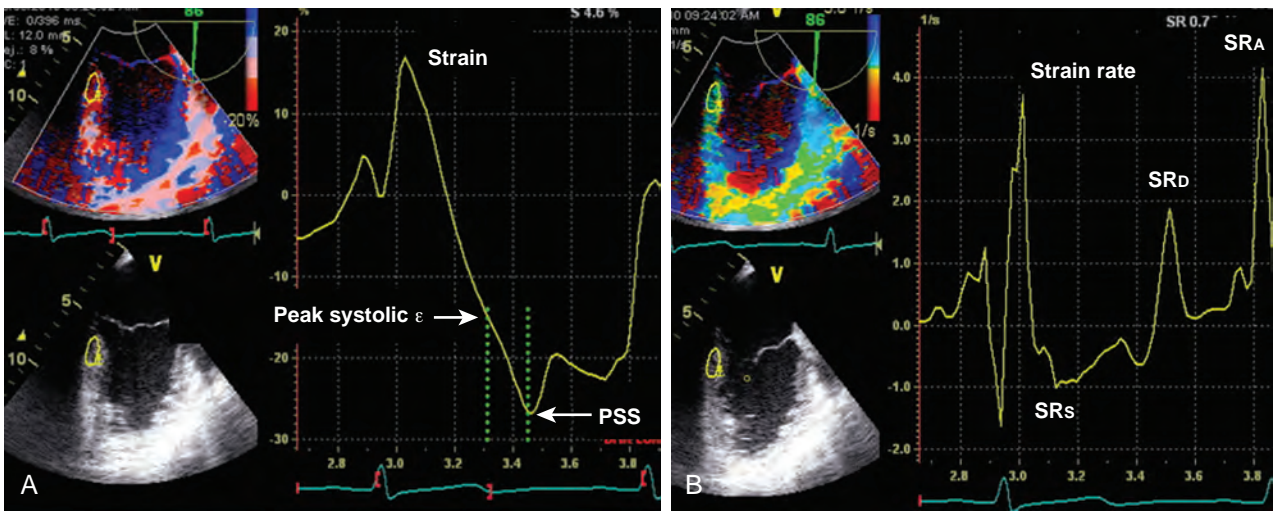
Measurement in Doppler strain echocardiography includes (A) peak systolic (SR_s), early diastolic (SR_d), late diastolic (SR_A) strain rates, and (B) end-systolic strain. Strain recorded after aortic valve closure is called *postsystolic strain (PSS)*.
